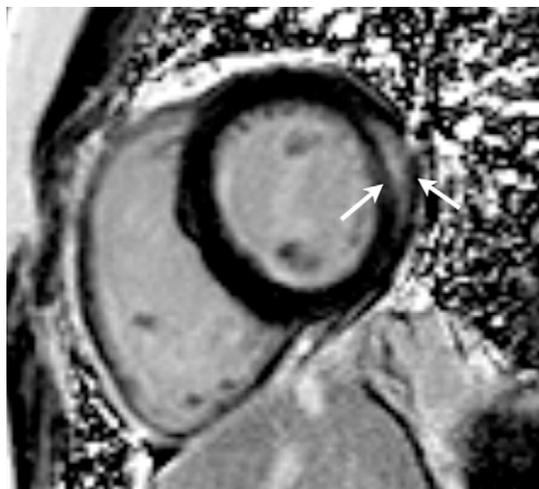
Delayed Enhancement Cardiac Magnetic Resonance Imaging in Trastuzumab-Mediated Cardiotoxicity
